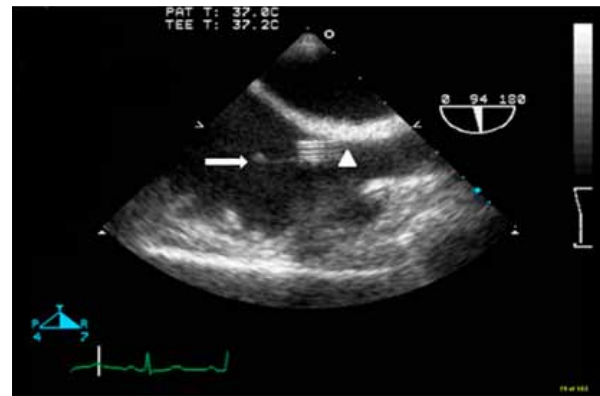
This transesophageal echocardiogram in the longitudinal plane shows the thrombus (arrow) attached to the indwelling venous catheter (arrowhead).
